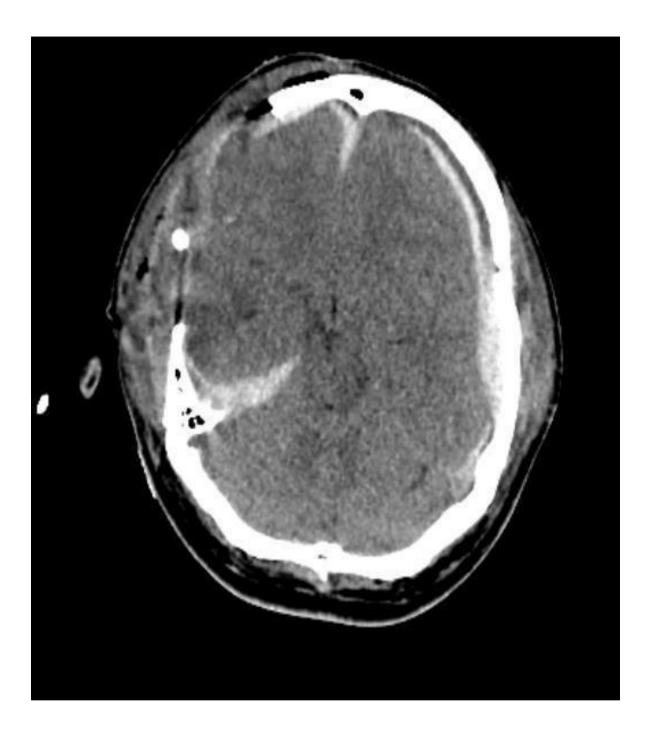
Axial CT scan brain demonstrates Subdural hemorrhage in the right tentorium, midline falx. SDH is also noted in Left fronto-temporal convexity. Craniotomy defect is noted in right Frontal bone.
